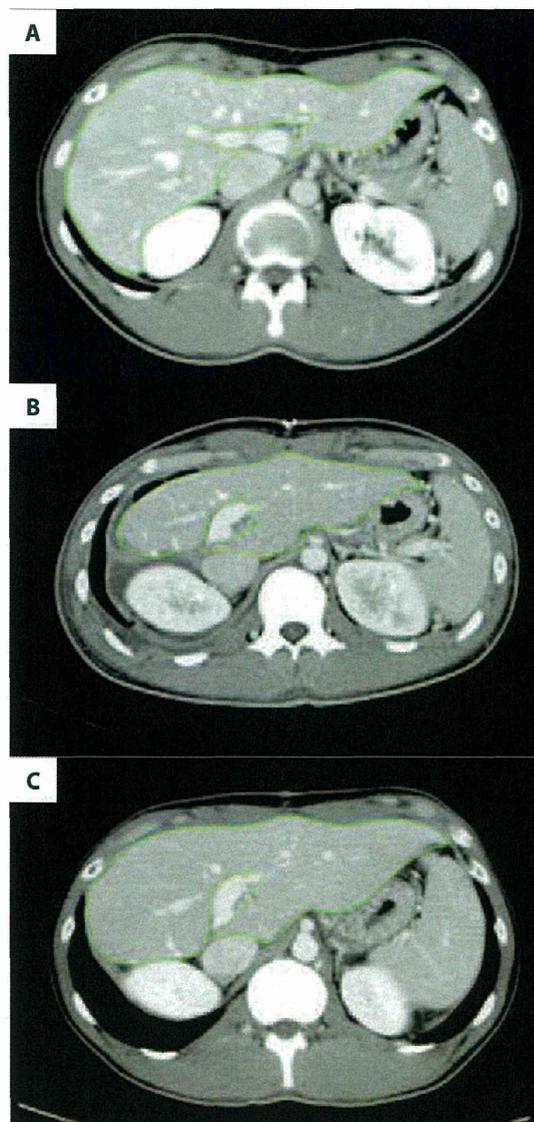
Contrast-enhanced x-ray CT. (A) Pre-hepatectomy. (B) Postoperative week 1. (C) Postoperative year 1. This donor underwent right lobectomy of 545 mL in size, corresponding to 47.2% of the preoperative volume. Follow-up CT (C) showed regeneration of the remnant liver to 99.5% of the preoperative volume.
